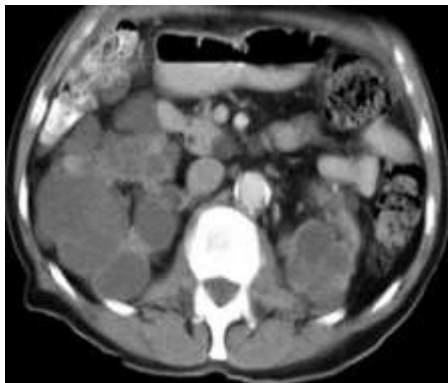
CT scan abdomen showing renal and pancreatic cysts
